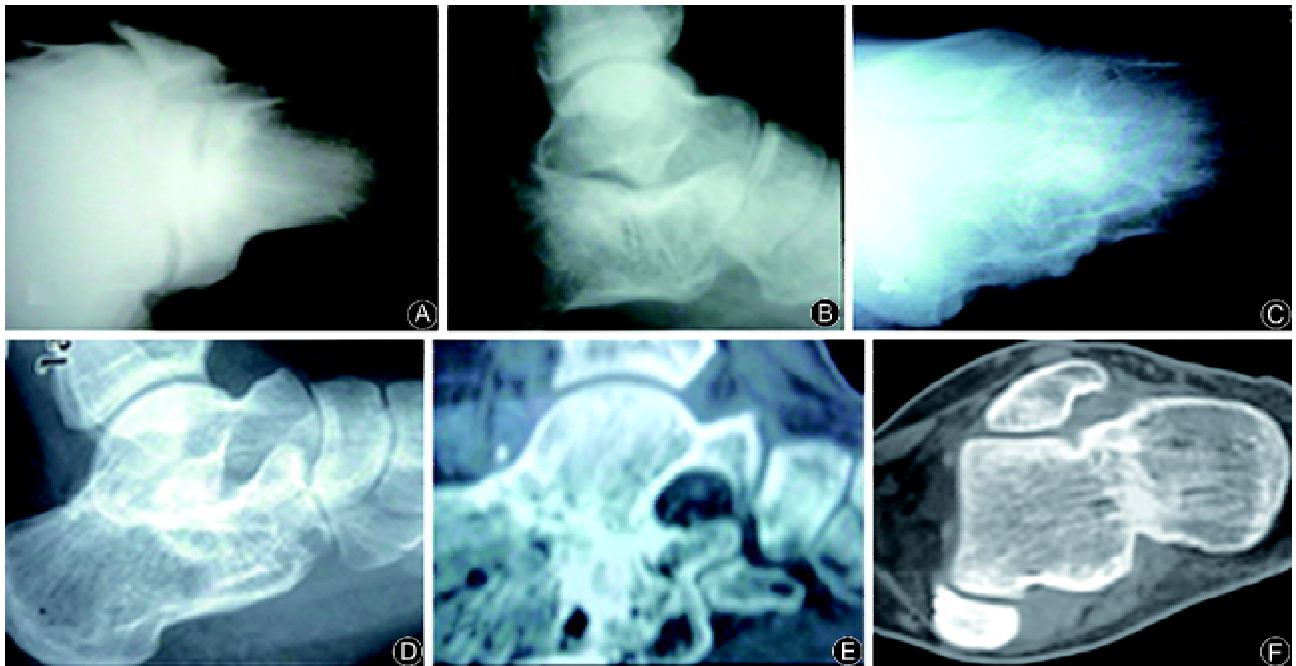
Radiologic observations of calcaneas before operation and 6 months after operation. A and B: Axile and lateral radiographs of calcaneas show the back clearance of talocalcaneal joints (before operation); C and D: Axile and lateral radiographs of calcaneas show the back clearance of talocalcaneal joints disappearing 6 months after operation; E and F: CT scans show no clearance between the talocalcaneal joints 6 months after operation.
